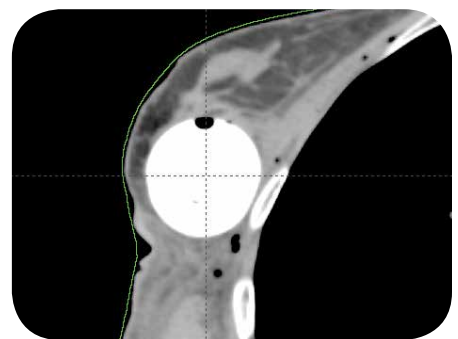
CT image of Cavity Evaluation Device (Hologic, Inc.) confirms insufficient cavity to skin spacing
